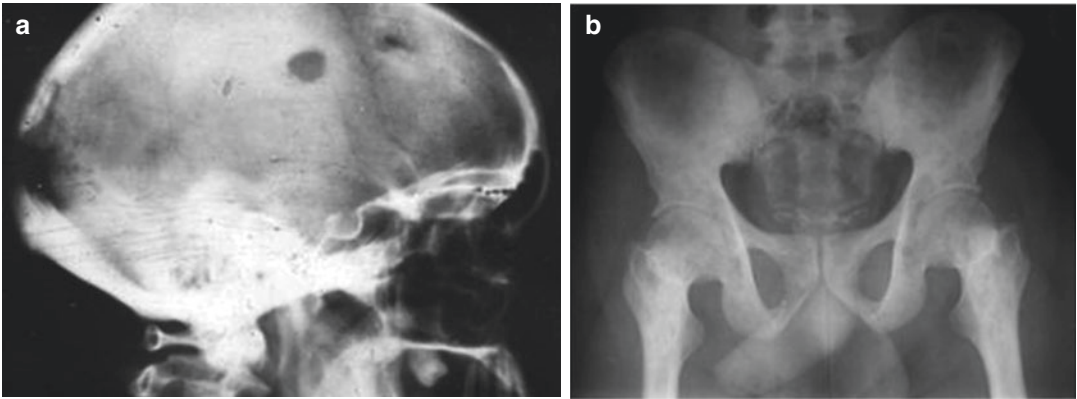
Erdheim-Chester disease. (a) Lateral radiograph of the skull shows a well-defined rounded radiolucent lesion with beveled edges in the parietal bone, with another similar lesion also noted in the frontal bone. (b)
